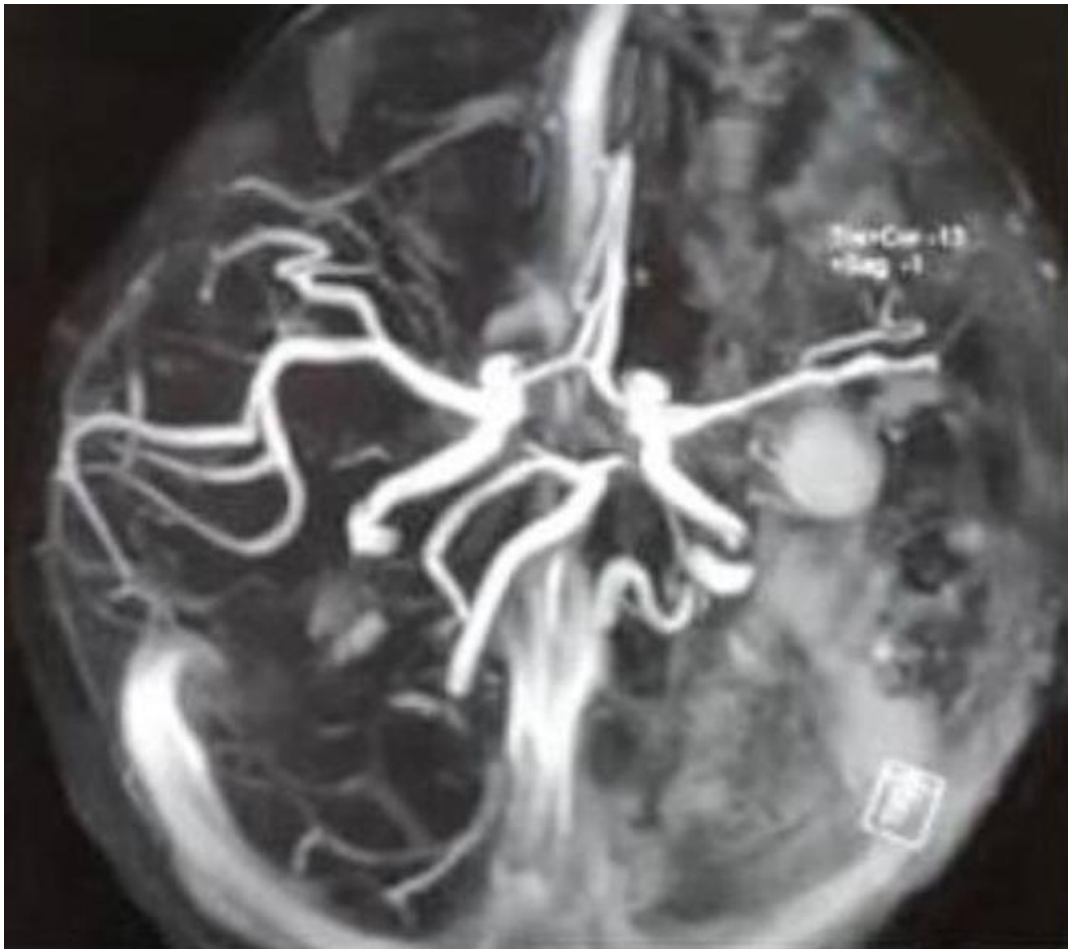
MRI & CT Angio showed Left temporal AVM measuring 1.1 x 0.5 x 0.7 cm draining into deep cerebral veins.
